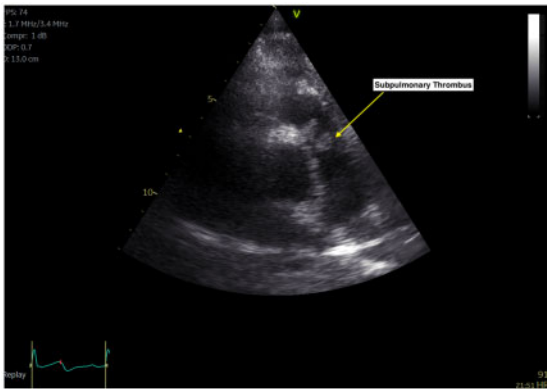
Pre-operative transthoracic cardiac ECHO demonstrating a sub-pulmonary thrombus and no intracardiac shunt.
